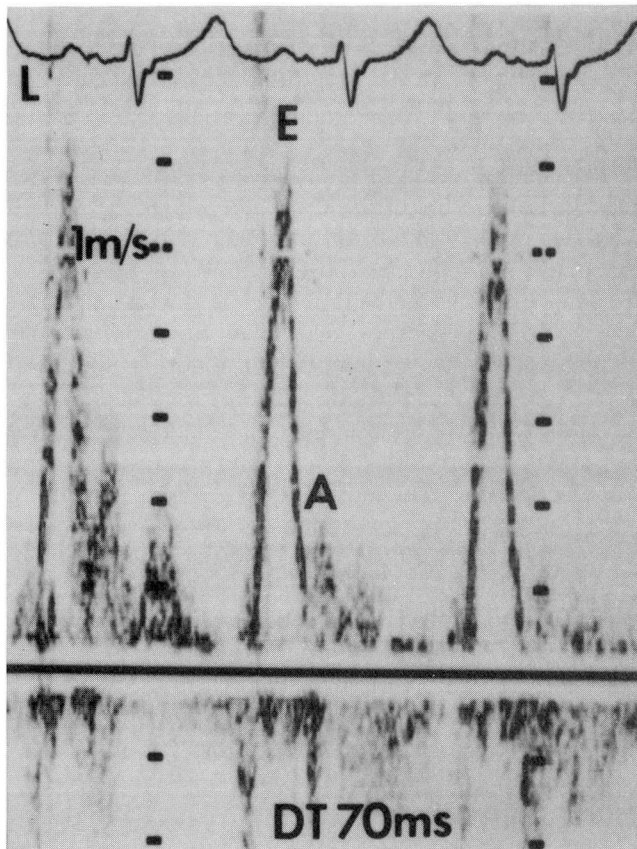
A pulsed-Doppler recording of the left ventricular inflow velocities in a patient with severe aortic regurgitation. The left ventricular inflow demonstrates a pattern of “restrictive physiology,” with an increased early (E)-to-late (A) filling wave ratio of 4.0 and a short deceleration time (DT) of 70 milliseconds.
